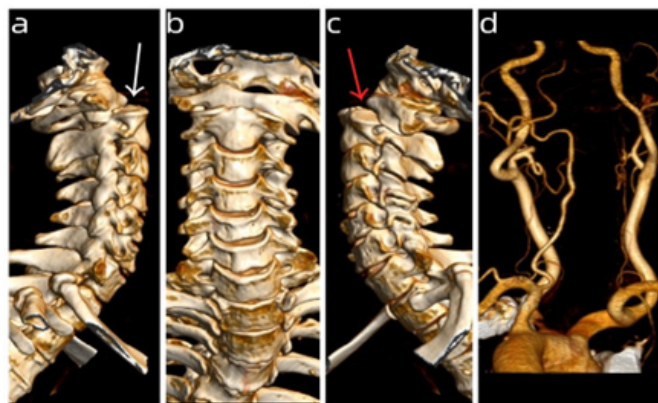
Preoperative 3D Computed Tomography reconstruction.
